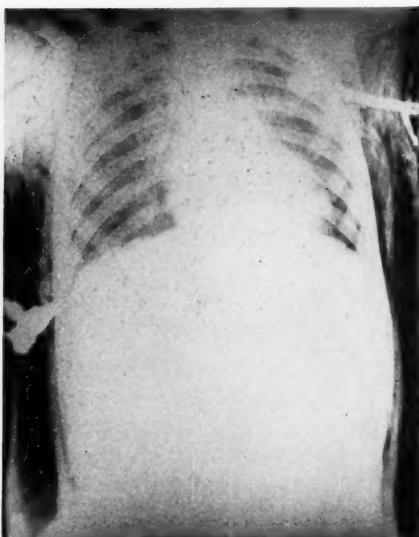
Antero-posterior chest x-ray (portable) after insertion of the catheter. The massive subcutaneous emphysema, the positions of the needle and catheter, and the superior mediastinal emphysema are shown. The lungs have re-expanded.
